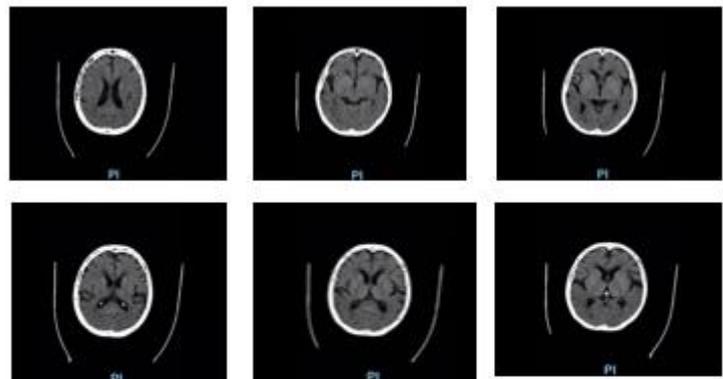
Non-contrast head CT scan showing a subacute ischemic infarction in the left external capsule, accompanied by cerebral atrophy and mild hydrocephalus.
